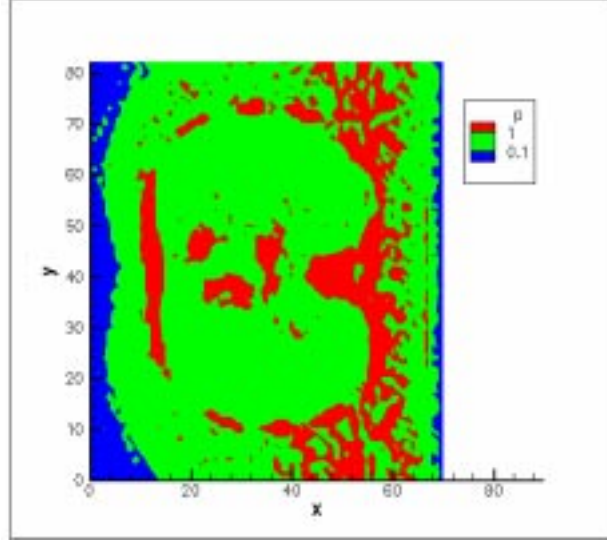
CT density image with regions with air density in blue.
